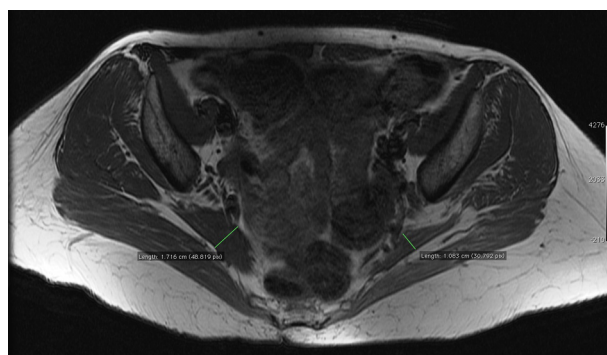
Axial T1-weighted cross-section. Thickness of the piriformis muscles measured in a 59-year old female treated with BT injection to the left piriformis muscle. Amyotrophy of the left piriformis (10.8-mm thick) compared to the right side (17.1-mm thick).
